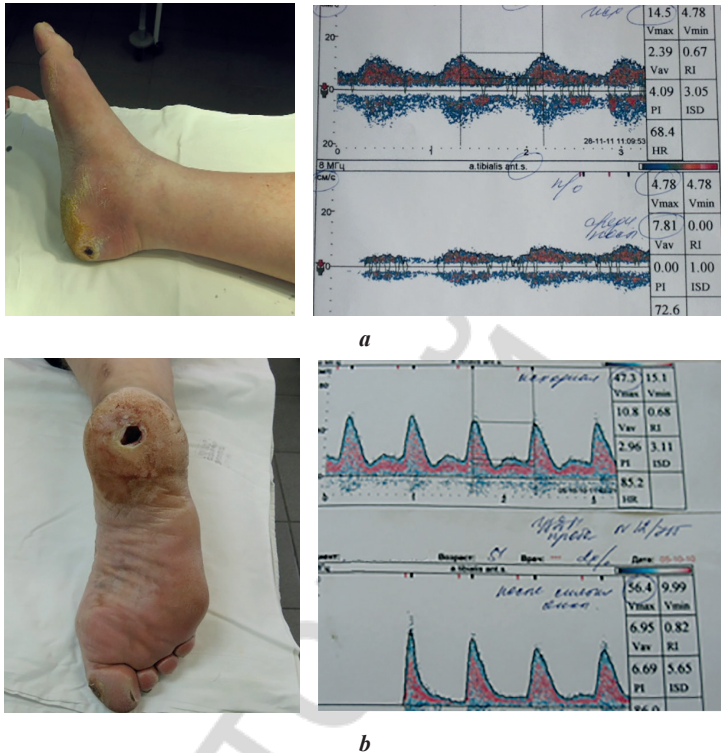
Ischemic (a) and neuropathic (b) foot ulcers and its Doppler arterial waveforms
